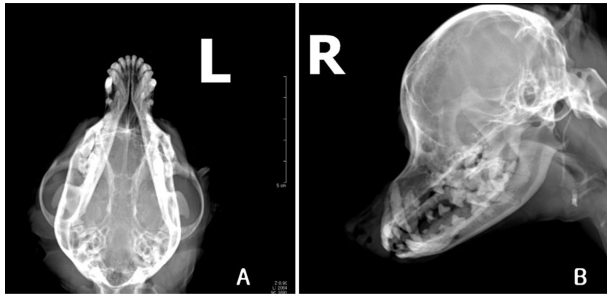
Radiography of the skull. Dorsoventral (A) and lateral (B) view. Radiographs revealed increased opacities on the right side of nasal cavity and irregular margins of nasal turbinate.
